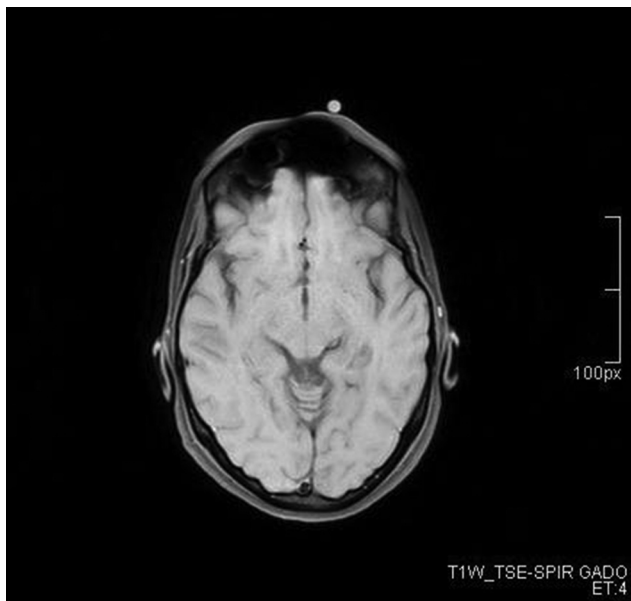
MRI Transverse view. Swelling left supraorbital marked with a vitamin capsule.
